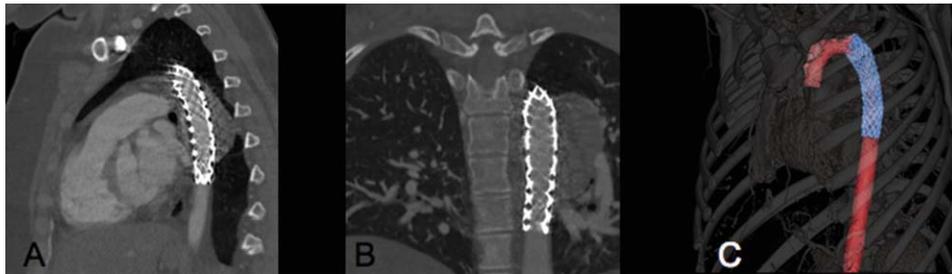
CT angiogram in sagittal oblique (A) and coronal (B) projections and volume rendered 3-D reconstruction (C) of the thoracic aorta with the covered stent excluding the aneurysm with no residual endoleak.
